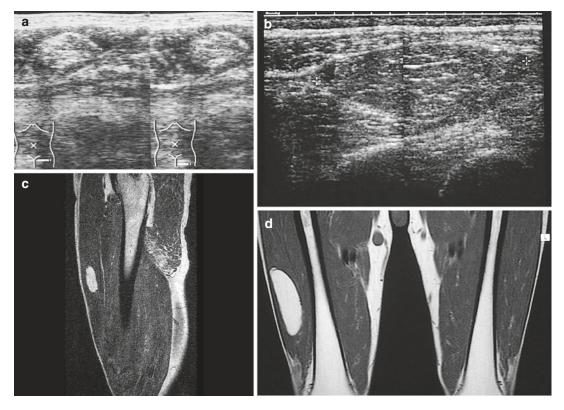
(a–d) Two cases of intramuscular lipoma of the thigh in a 57-year-old man (a, b) and in a 66-year-old man (c, d). (a) US of the thigh. (b) Sagittal spin-echo T1-weighted MR image. (c) US of the thigh. (d) Coronal spin-echo T1-weighted MR image. Two examples of intramuscular lipoma showing a characteristic elongated
